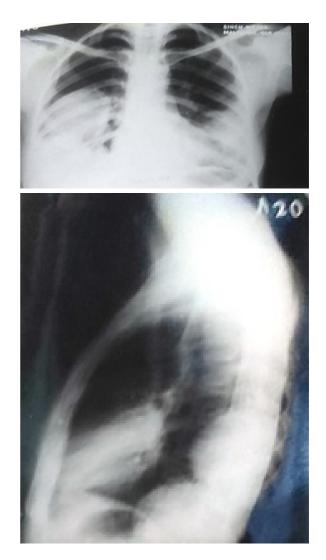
Radiograph of a 25 years old female patients showing multiple infected bilateral hydatid cysts
